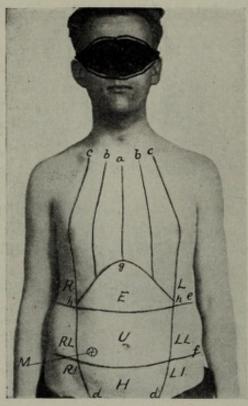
Lines and regions of the ventral thoracic and abdominal walls. (From a Photograph.) a, Midsternal; b, b, parasternal; c, c, midclavicular lines; e, subcostal line; f, intertubercular lines; g, subcostal angle; hd, hd, midinguinal lines. RL right and left hypochondriac regions; RL, LL, right and left lumbar regions; RI, LI, right and left inguinal regions; E, epigastric; U, umbilical; H hypogastric regions; M, McBurney's point.
